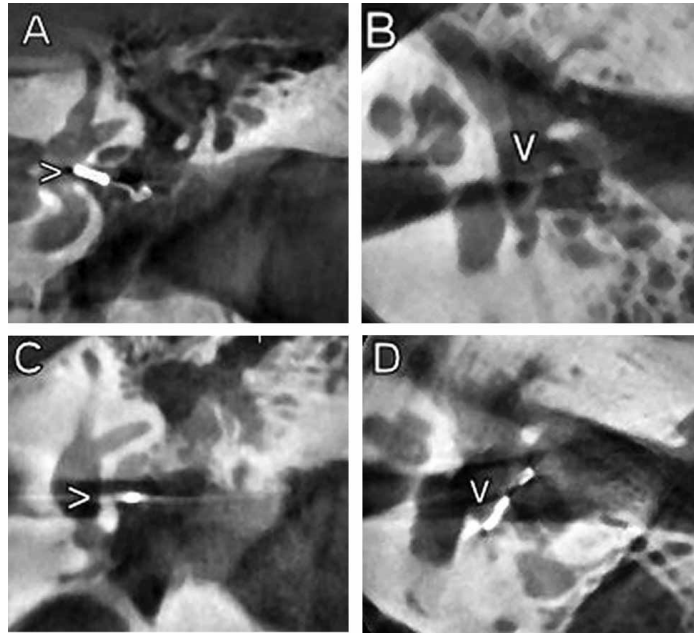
Temporal bone CBCT image (from [Peltonen 2009]) acquired to investigate postoperatively an ossicular prosthesis (arrow).
